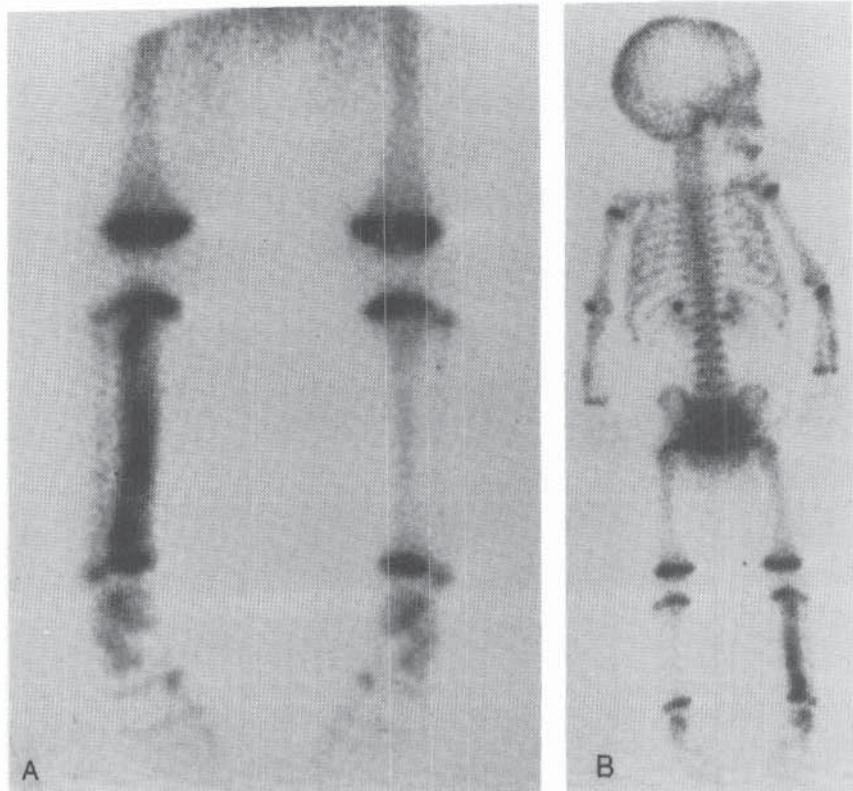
Scintigraphic findings in battered child syndrome. A, An anterior scintiphoto of the lower extremities of a child who sustained the sudden onset of a limp revealed increased uptake in the right tibia, suggesting a toddler's fracture. B, A posterior whole-body scintiphoto revealed abnormal uptake in both forearms and an epitrochlear fracture of the left arm. Multiple rib abnormalities are suggested as well. Psychosocial evaluation uncovered evidence of child abuse. (From Harcke HT, Mandell GA: Musculoskeletal scintigraphy. In Miller JH, Gelfand MJ (eds): *Pediatric Nuclear Imaging*. Philadelphia, WB Saunders Co, 1994.)
